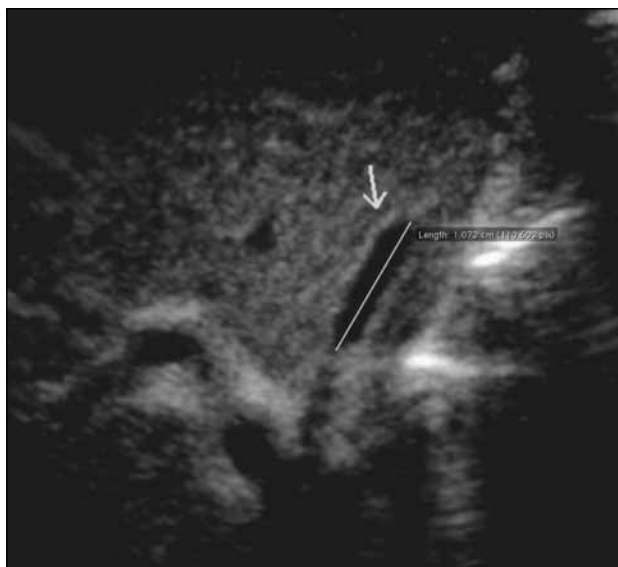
Ultrasonography showing a small gallbladder (arrow) measuring less than 1.5 cm in length.
